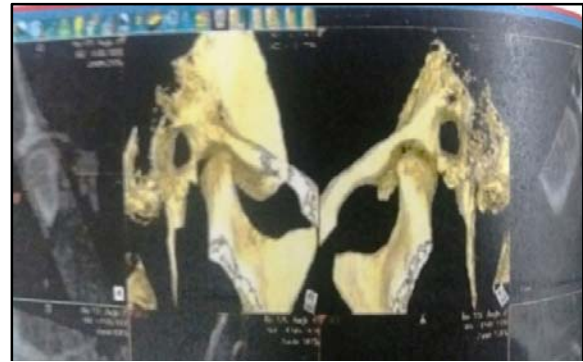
TMJ image reconstructed with Cone beam computed tomography
